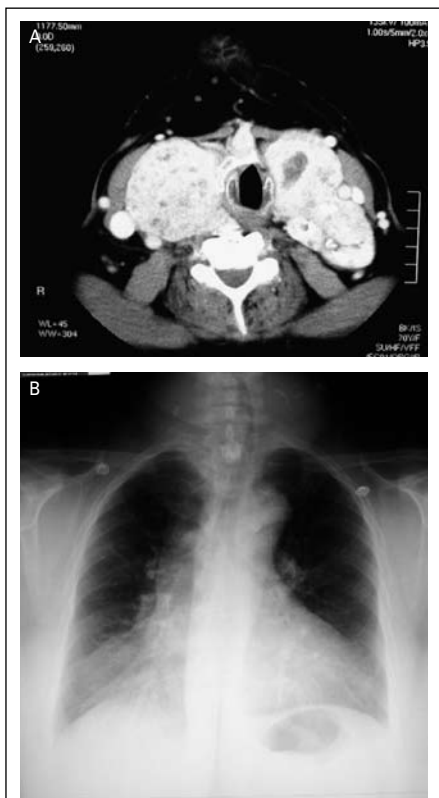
CT scan and chest X-ray showing narrowing and deviation of the trachea due to a massively enlarged right lobe of the thyroid gland. These images are of the patient shown in Figure 1
